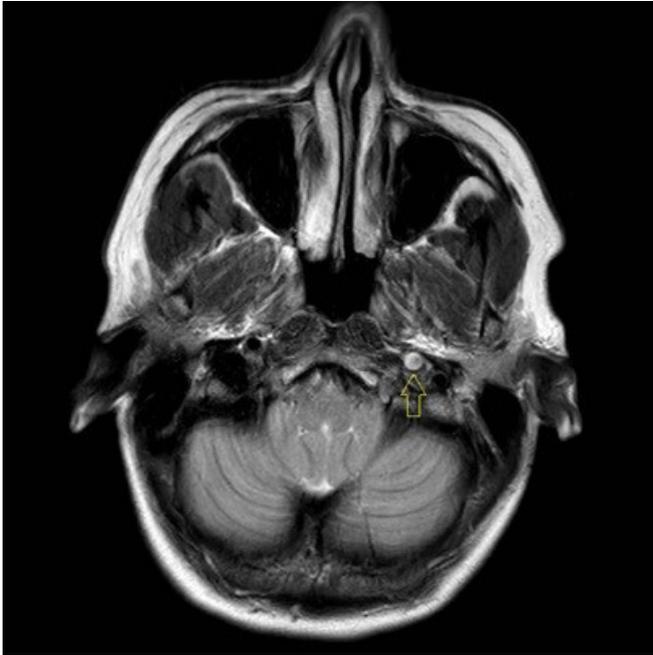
Magnetic resonance imaging. Yellow arrow: absence of emptied flow at the level of the petrous and cavernous portion of the left internal carotid artery.
